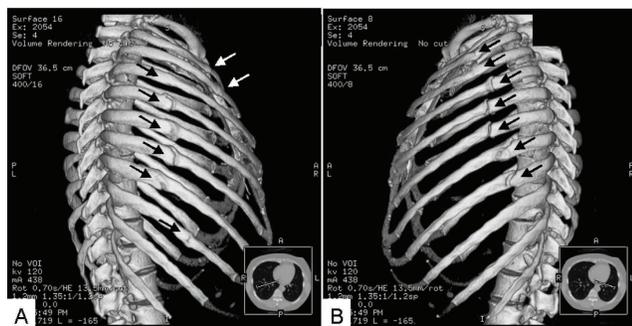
Multiple fractures (arrows) of the right 2nd to 9th ribs (A) and left 2nd to 8th ribs (B) on three-dimension computed tomography.
